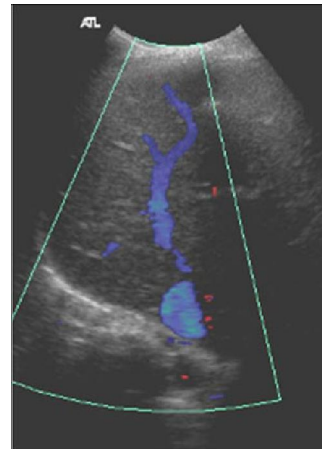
Color Doppler in 25 years old male patient with Primary BCS due with partially thrombosed IVC. Incomplete color filling of the IVC lumen with intrahepatic collateral vessels.
